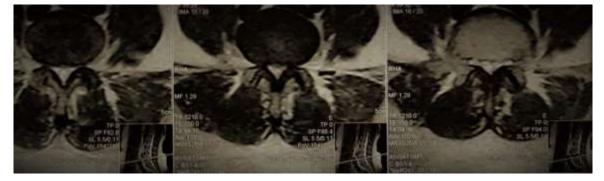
preoperative axial Lumbosacral MRI, cuts through L4/L
